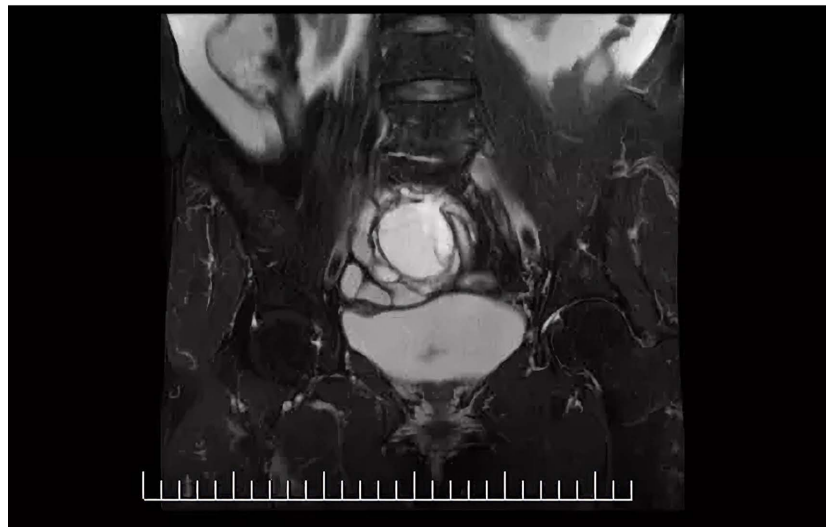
MRI OCor T2 fs FSE image: High-signal shadows can be seen in the abdominal and pelvic cavities.
